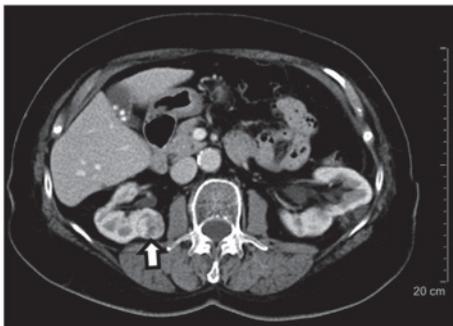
Follow-up abdominal computed tomography scan 2 years after chemoradiotherapy for lymphoma. An enlarging new lesion in the right kidney (arrow) was identified (renal cell carcinoma metastasis).
